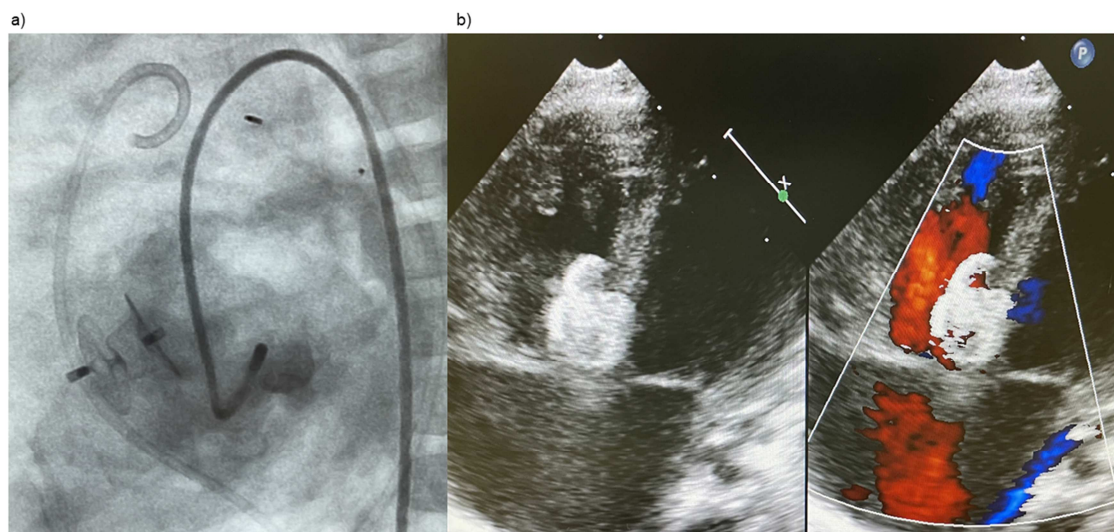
a). Final angiography is shown in lateral 90° projection; in addition to an MFO-device placed in the VSD, the MVP-device within the arterial duct as well as a second pigtail catheter still in the pulmonary artery are depicted. b). postprocedural echocardiography four chamber view without and with colour confirm the correctly placed Occluder.
